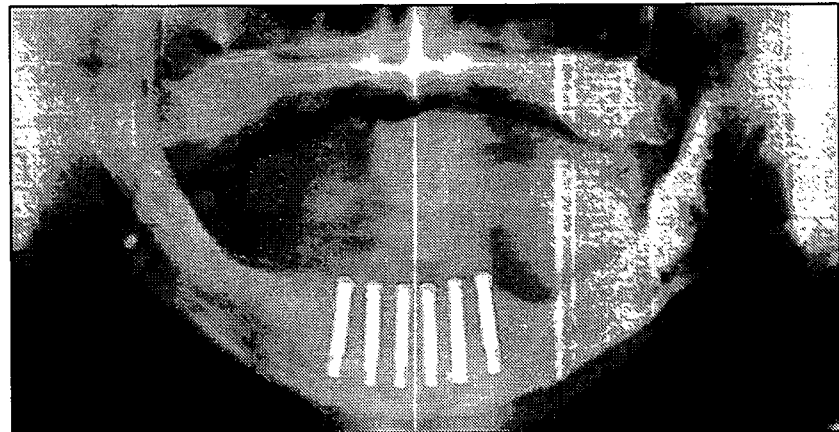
Radiograph obtained immediately after implant placement.
